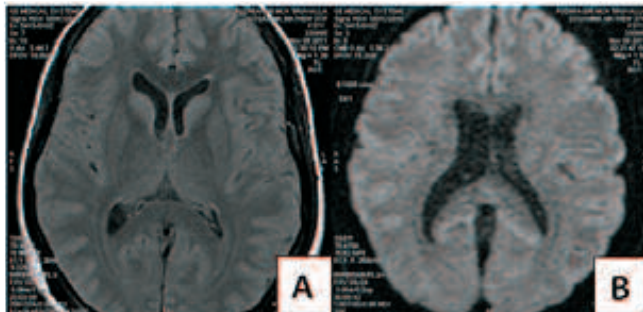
A) FLAIR B) Diffusion weighted
